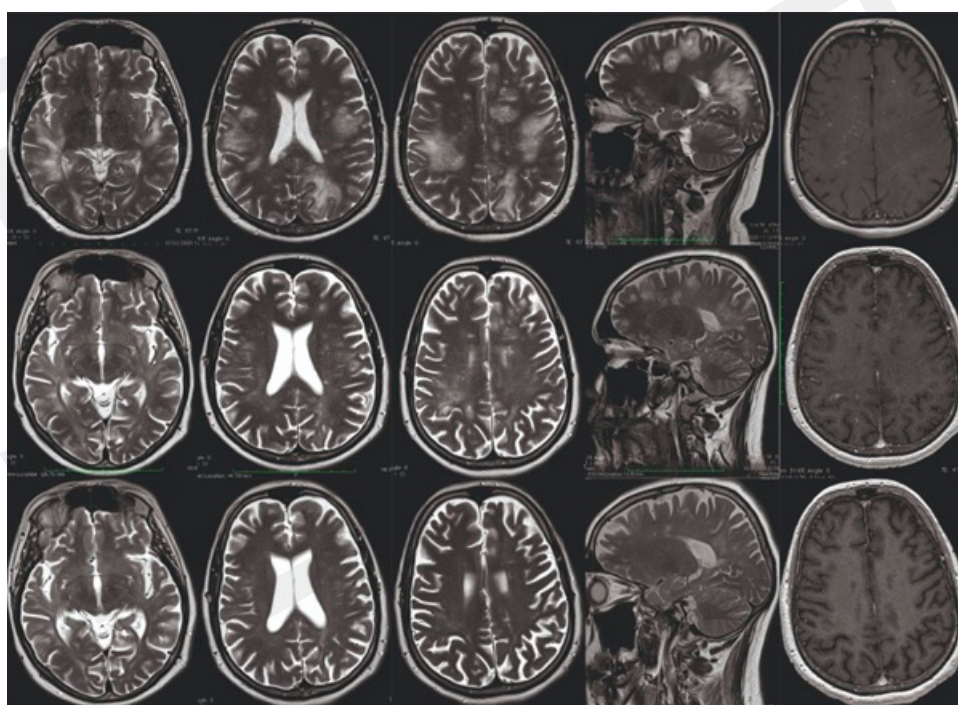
MRI of the brain, axial and sagittal view, T2-weighted images and T1-weighted images with contrast (last column), February 2020 – upper row, June 2020 – middle row, and June 2021 – bottom row
